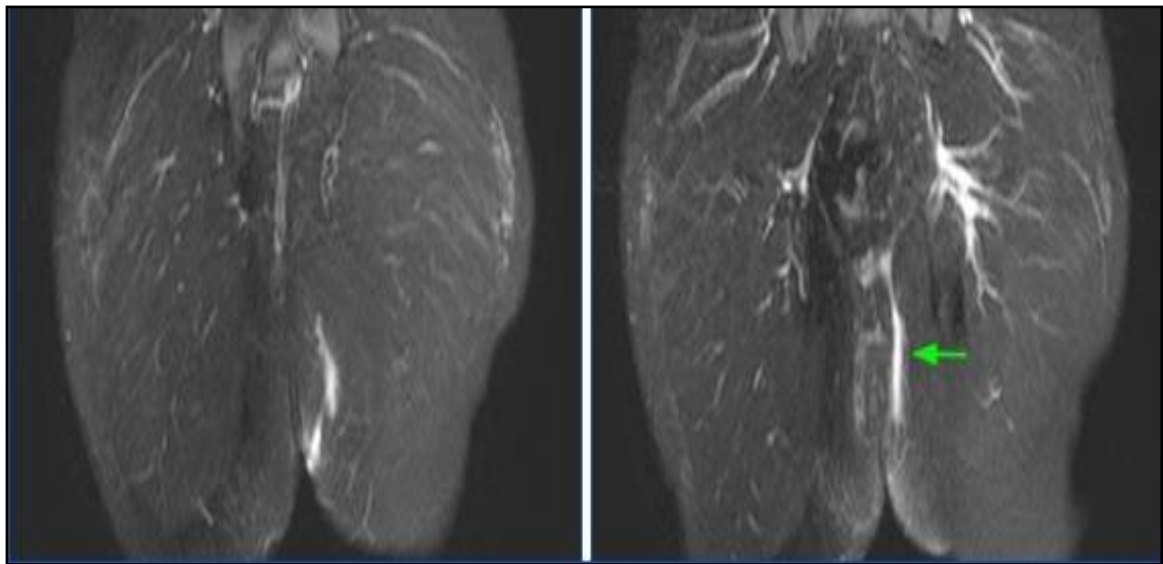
T2 FLAIR Coronal - Transsphincteric Fistula Grade III
